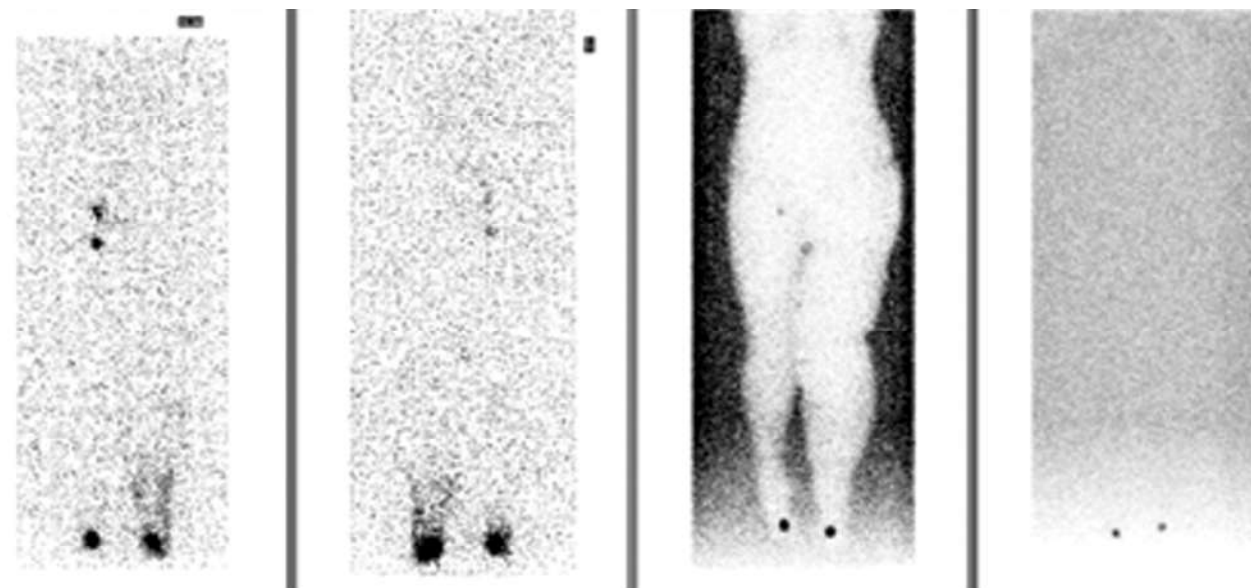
Lymphoscintigraphy image.
